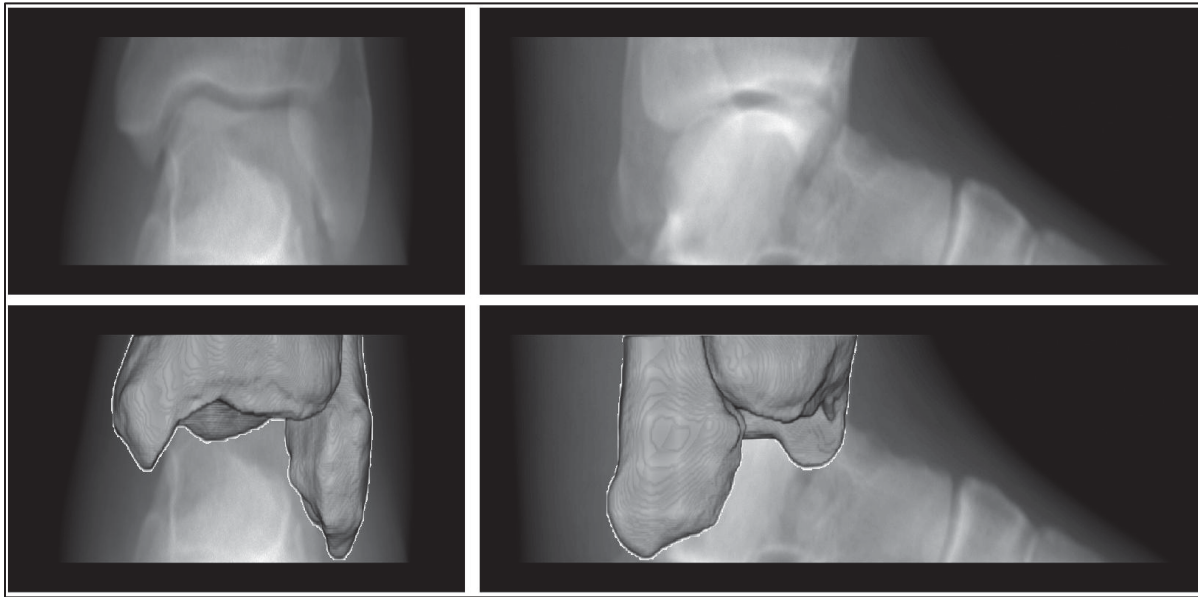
Ankle biplanar radiographs, having the tibiofibular joint highlighted
